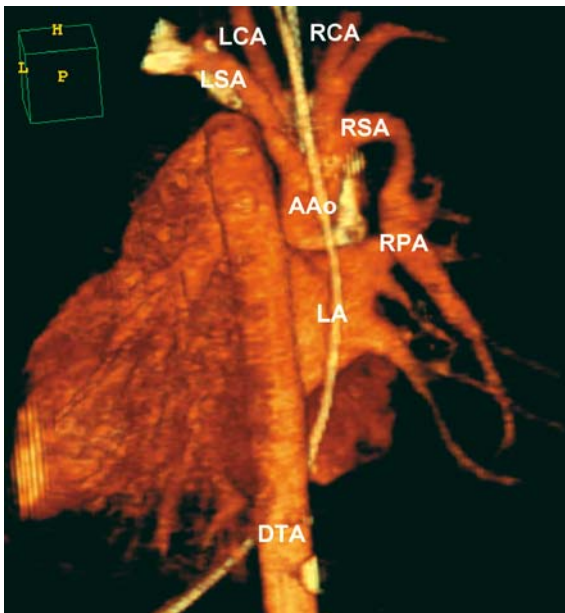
Aortic arch interruption. CT scan posterior coronal view, volume rendering imaging, showing type A aortic arch interruption, distal to the left subclavian artery, in a neonate with anomalous origin of the right pulmonary artery from the right subclavian artery (AAo ascending aorta, DTA descending thoracic aorta, LA left atrium, LCA left carotid artery, LSA left subclavian artery, RCA right carotid artery, RPA right pulmonary artery, RSA right subclavian artery) (photograph courtesy of Dr. Mohammed Tawil)
